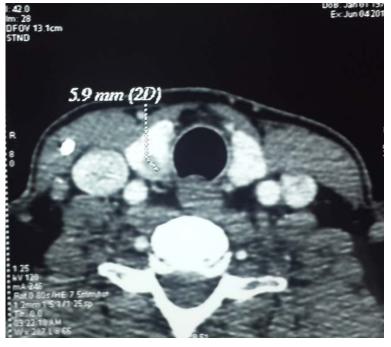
CERVICAL CT SCAN SHOWING A NODULAR THYROID
